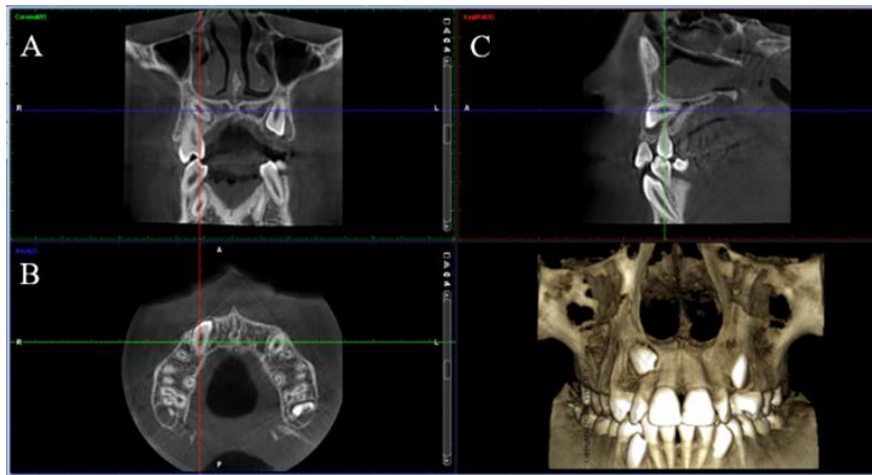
The three-dimensional reconstructed image acquired from raw CBCT data; (a) Coronal view, (b) Axial view, and (c) Sagittal view.
